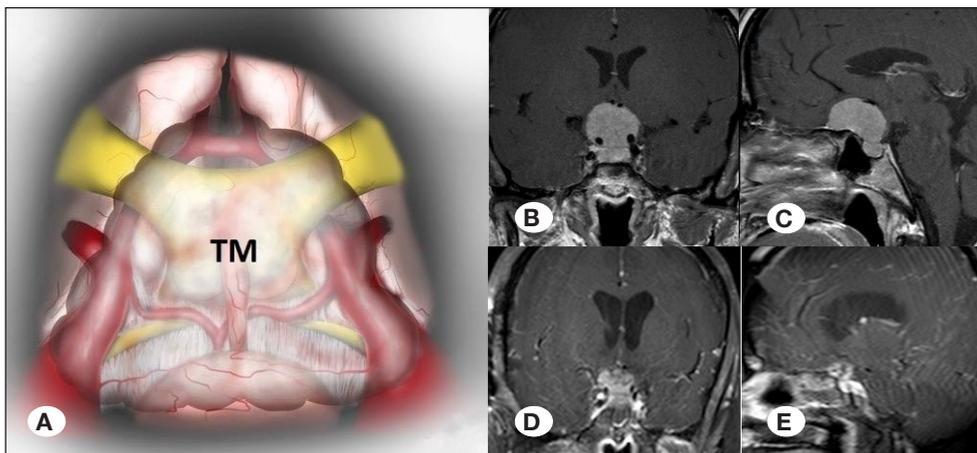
Tumor outside the infrachiasmatic corridor and MR images. A) Tumor outside the infrachiasmatic corridor. B) Preoperative coronal T1-contrast-enhanced MR image of a patient with tumor which outside the infrachiasmatic corridor. C) Preoperative sagittal T1-contrast-enhanced MR image of a patient with tumor which outside the infrachiasmatic corridor. D) Postoperative coronal T1-contrast-enhanced MR image of same patient. Residual tumor tissue is seen above the right carotid artery. E) Postoperative sagittal T1-contrast-enhanced MR image of same patient. TM: Tumor.
